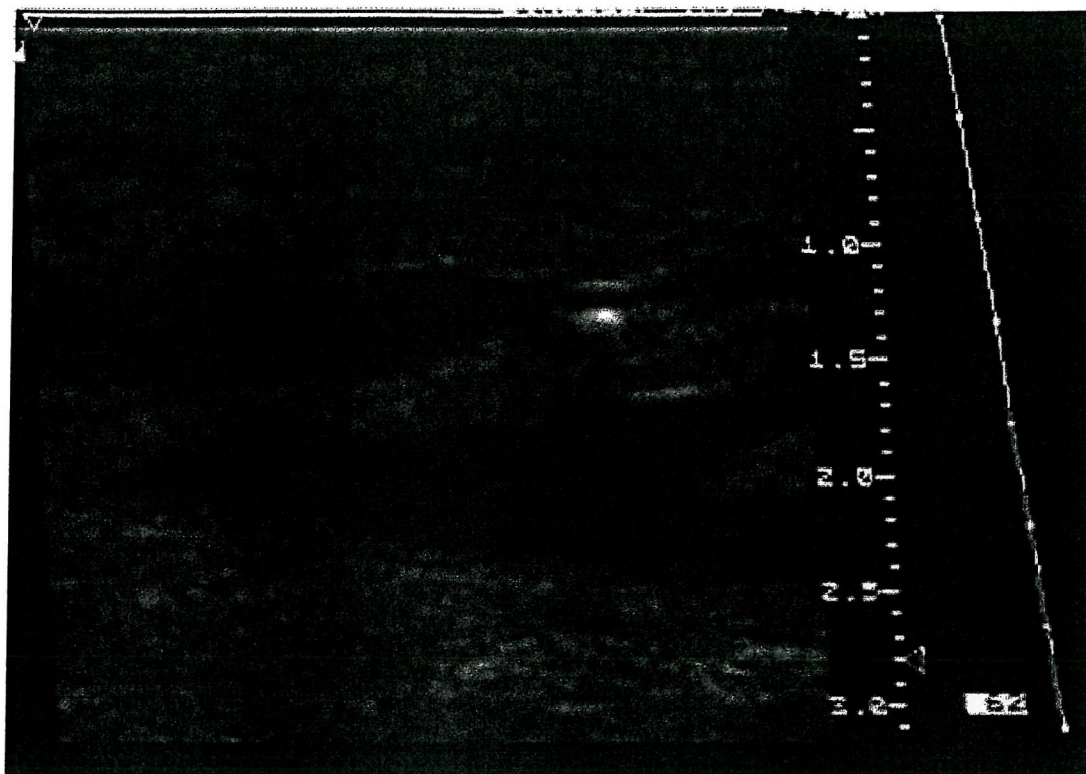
A sonographic image of oedema in the gaiter region of the ankle in patient with CVI using 7.5MHz ultrasound probe. Hypoechoic areas in the image are pockets of oedema both in superficial and deeper areas.
